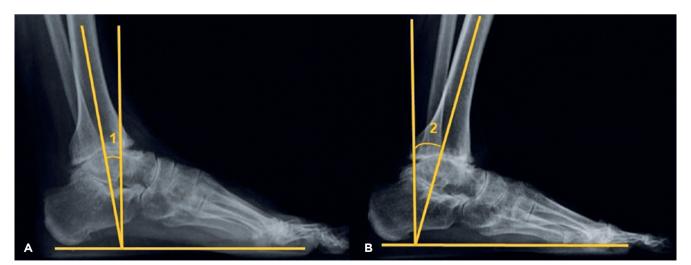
Method for radiographic measurement of ankle range of motion. In figure "A" we can see angle "1", which represents maximum plantar flexion, measured through the difference between the angle formed by the long axis of the tibia with the ground, and the right angle (neutral) of 90° with the ground. In figure "B" we can see angle "2", which represents maximum dorsiflexion, measured through the difference between the angle formed by the long axis of the tibia with the ground. In figure "B" we can see angle "2", which represents maximum dorsiflexion, measured through the difference between the angle formed by the long axis of the tibia with the ground, and the right angle (neutral) of 90° with the ground. The sum of the two angles (1 + 2) represents the total range of motion of the ankle being assessed.
